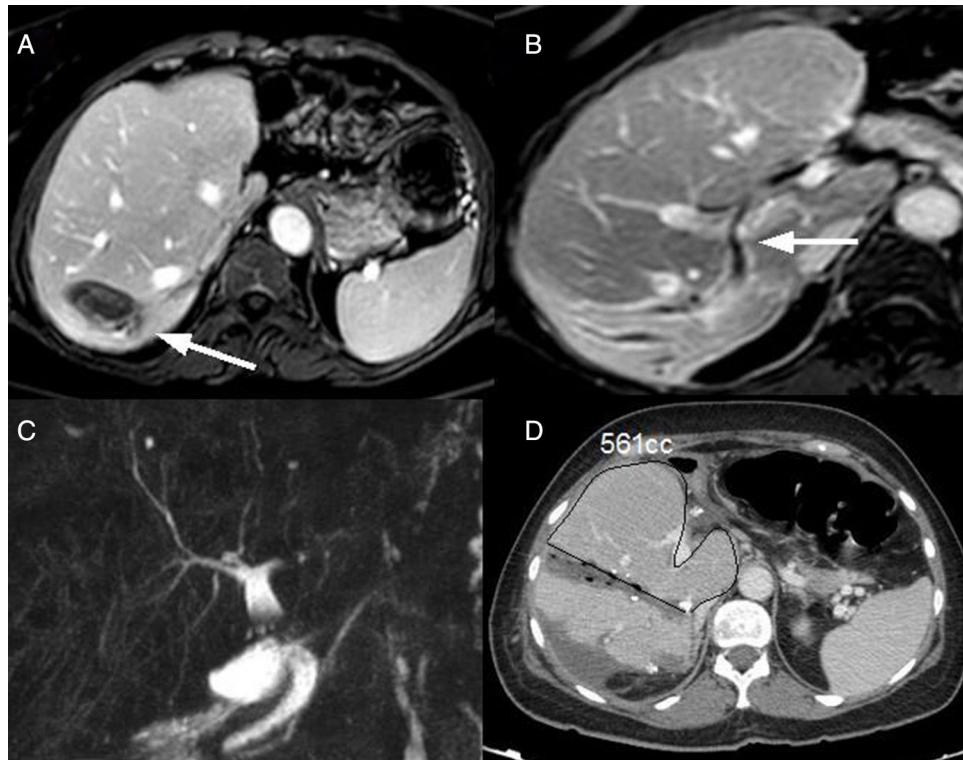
(A) Metastasis in segment 7; (B) infiltration of the right posterior bile duct (arrow indicating infiltration limit 21 mm from the anterior duct); (C) MRCP with no dilatation or stenosis; (D) volume CT on the 7th day post-op after the first stage
